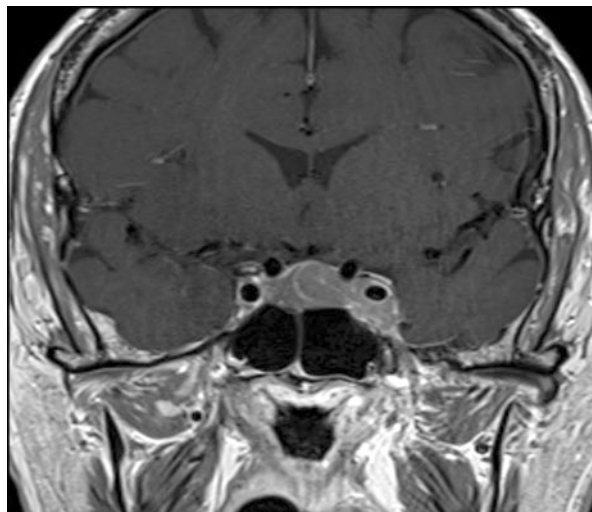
T1-weighted MRI with gadolinium depicting a suprasellar extension of a pituitary tumor with compression of the inferior optic chiasm in the (a) coronal and (b) sagittal views
